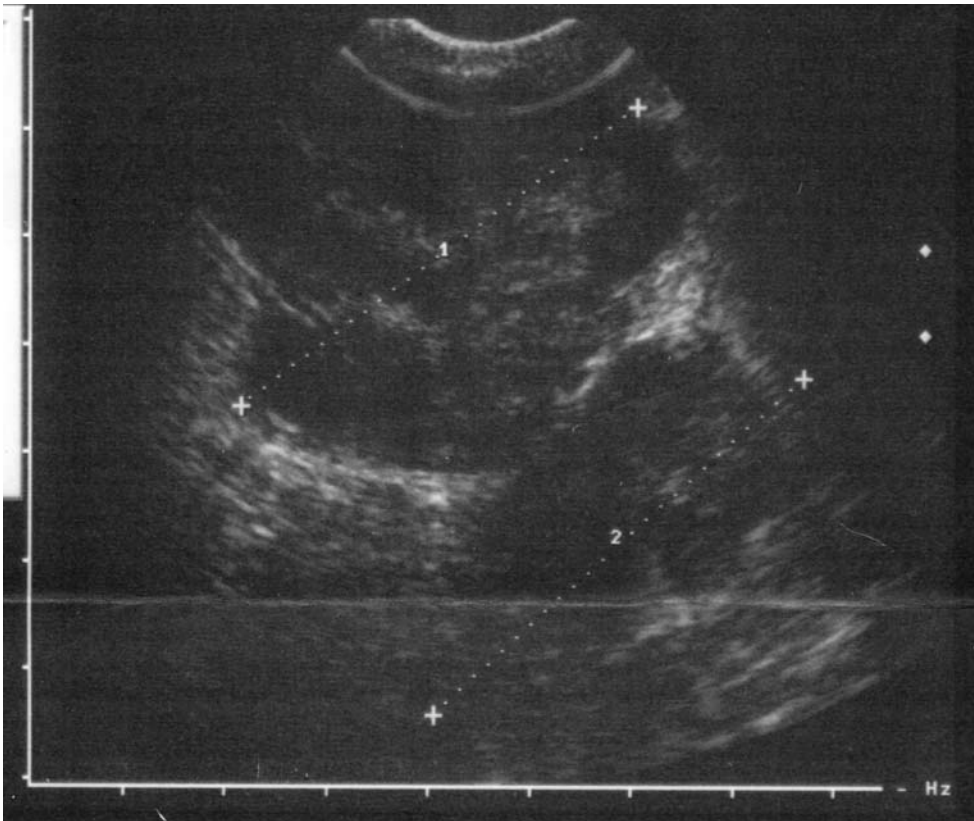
Ultrasonographic appearance of two non-connected melanomas of colon and rectum, distorting normal architecture of the organs.
